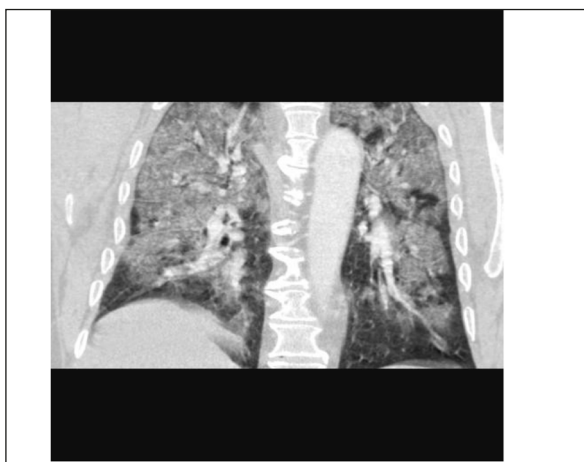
Coronal contrast-enhanced CT scan shows bilateral ground glass opacities.
